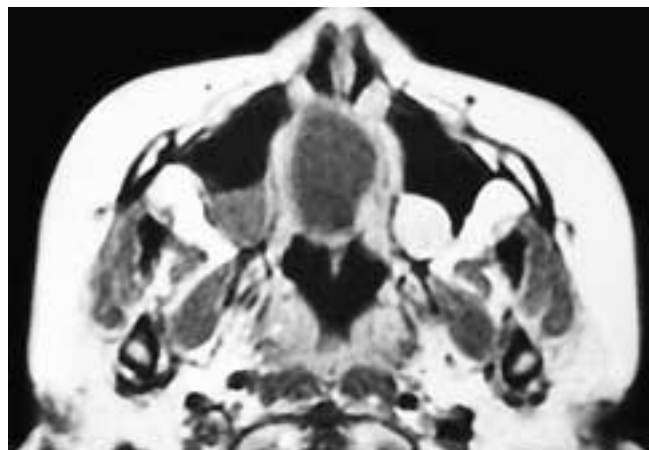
Axial T1-weighted MR image shows an expansile process that arose in a pneumatized middle turbinate (concha bullosa). This mucocoele has a low T1-weighted signal intensity and had a high T2-weighted signal intensity. Also present is a small retention cyst in the posterior recess of each antrum. On the right side the cyst has low T1-weighted signal intensity, while on the left side the cyst has intermediate signal intensity. This patient had a mucocoele of a concha bullosa.
